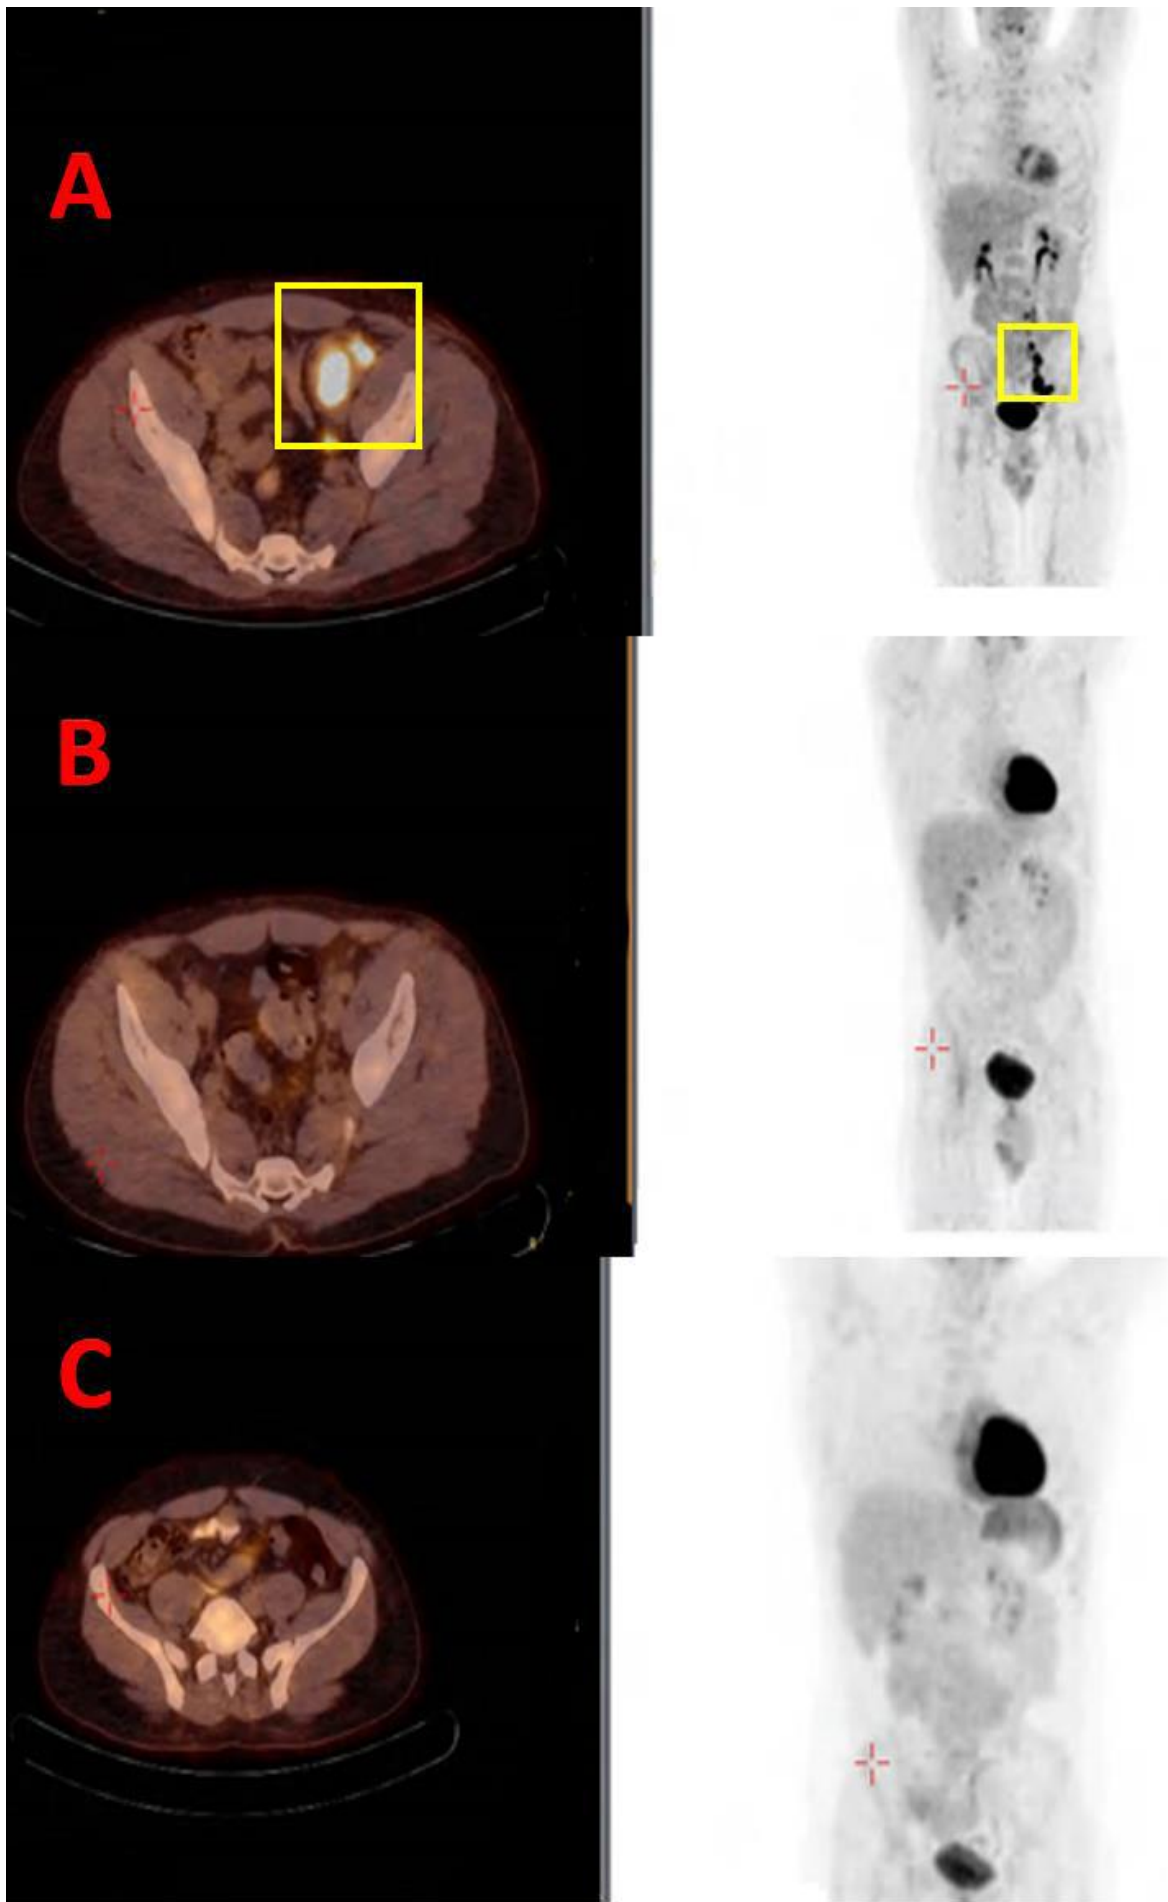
Shows the patient's radiological response (PET-CT selections) to the treatment. (Yellow squares- hyper-metabolic uptake and lymphadenopathy of the left iliac areas.
